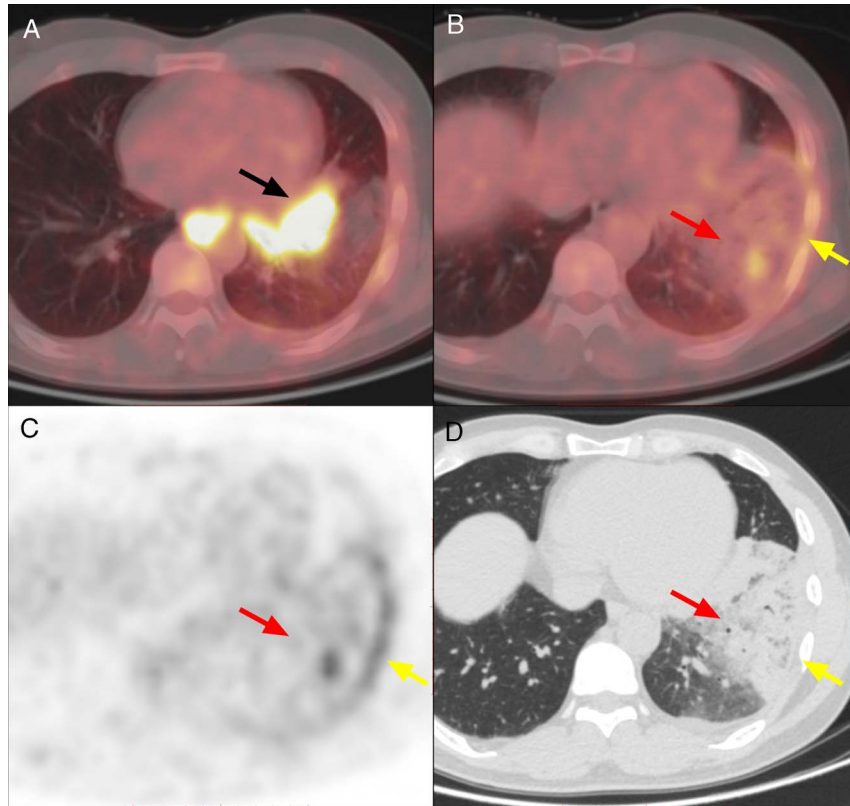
A 36-year-old man with lung adenocarcinoma of the right hilum. Axial PET/CT (A) showed an FDG hypermetabolic mass ($SUV_{max} = 18.8$) in the left hilum (black arrow). Axial PET/CT (B), PET (C), and thin-slice chest CT (D) showed a pulmonary infarction in the upper lobe of the left lung with mild heterogeneous hypermetabolism (red arrow) ($SUV_{max} = 7.9$). Linear FDG hypermetabolism was observed along the left pleura (yellow arrow) ($SUV_{max} = 5.0$).
